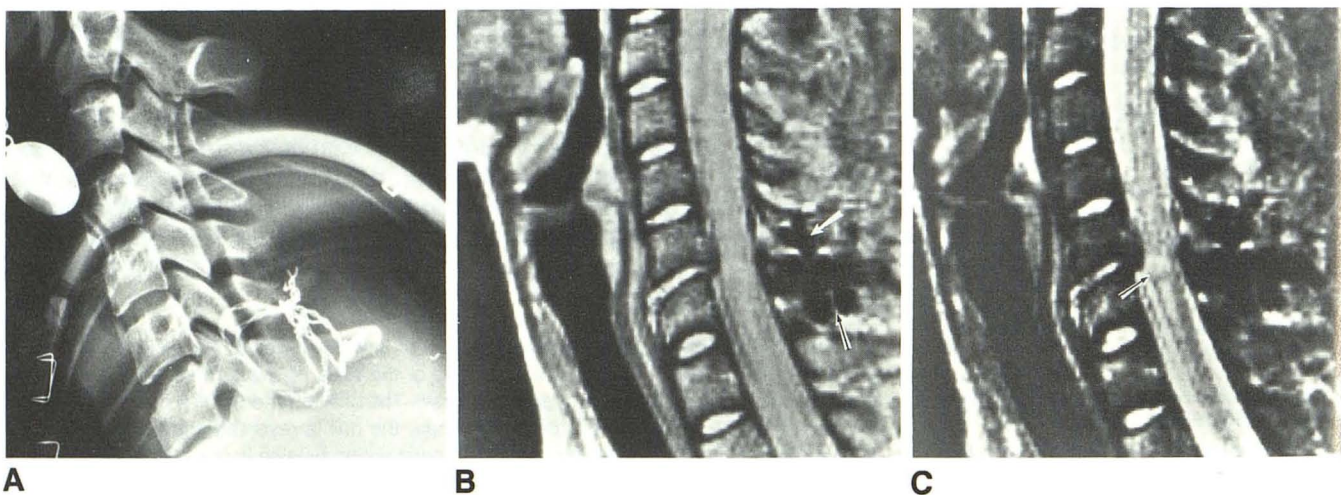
MR images after cervical spine fixation with titanium wire.
